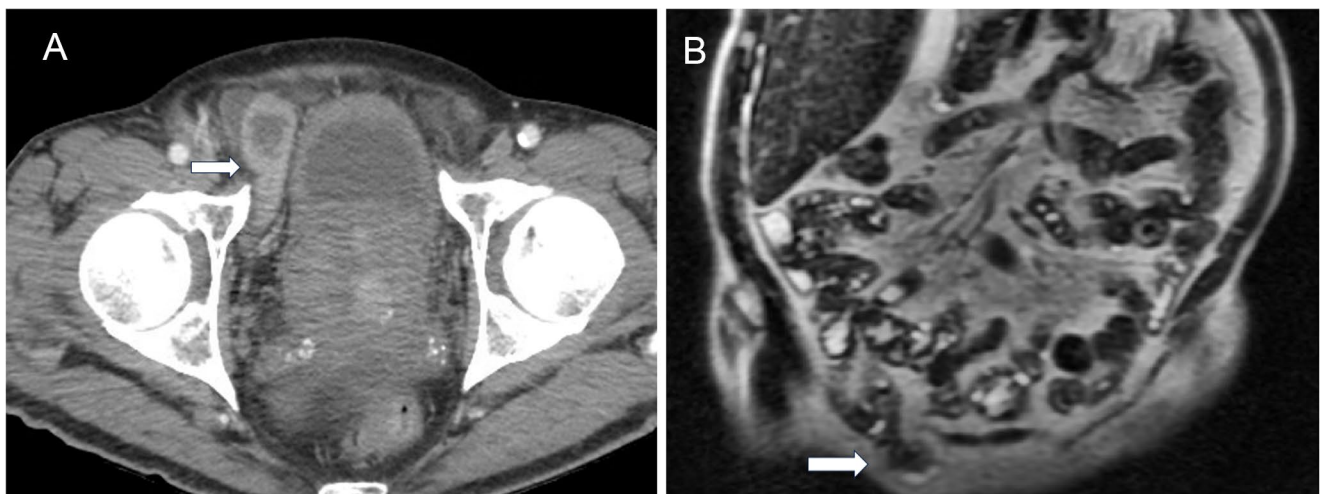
A CT section of the pelvis in this 75-year-old man with prior partial gastrectomy for cancer demonstrates a Meckel's diverticulum in the right inguinal hernia (arrow). B Coronal image of abdominal MR in T2 sequence also shows the herniated diverticulum (arrow)
